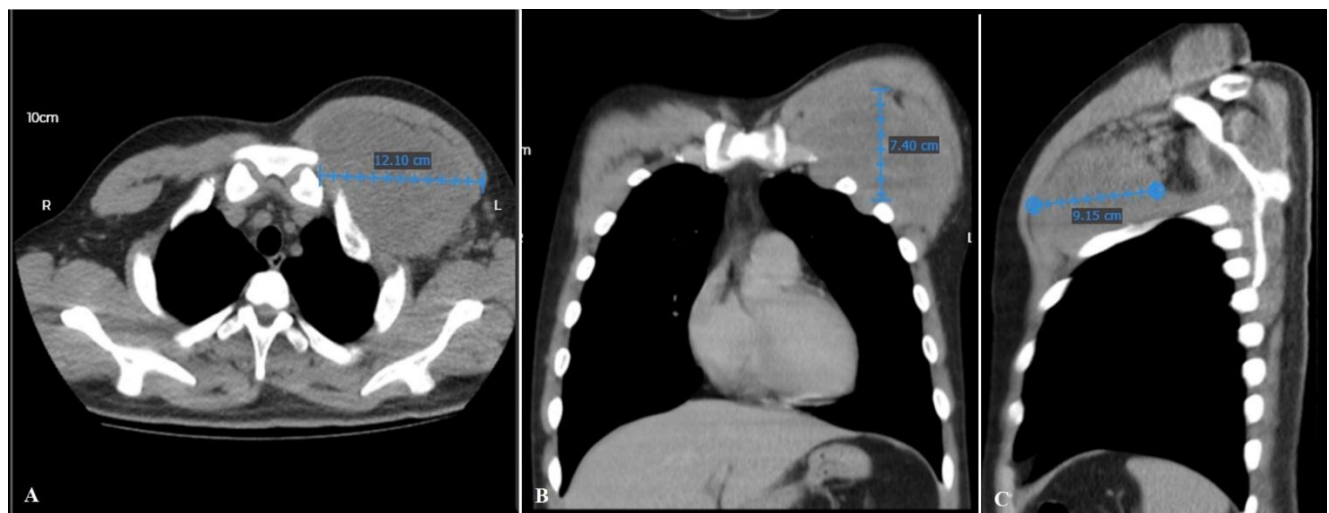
Contrast-enhanced thoracoabdominal CT scan. A: Transverse view. B: Coronal view. C: Sagittal view. It showed an ovoid tumor measuring 9.15 x 12.1 cm with invasion in the deep plane of the pectoralis major and minor muscles. The measurements are shown with the blue line in cm.
